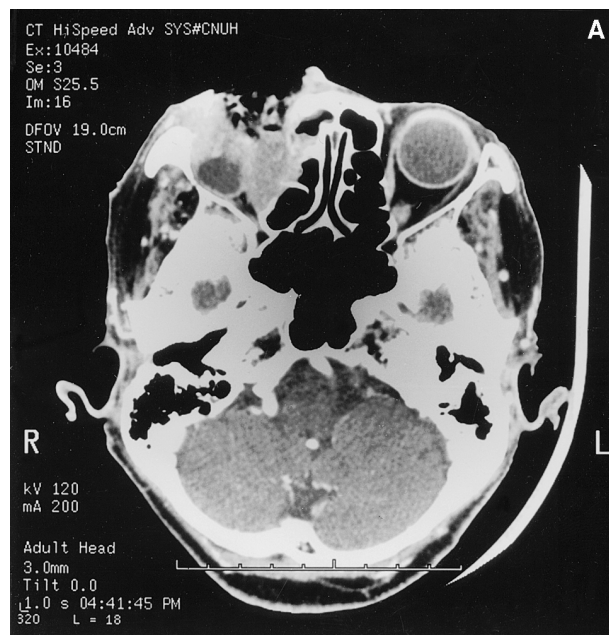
(A) Orbital sagittal computed tomographic scan showed mass in extraconal space of right orbit with extension to adjacent sinus cavity without brain involvement. It was surmised that remnant of eyeball remained in intraconal space. (B) Orbital coronal scan showed homogeneous mass, with extension to adjacent sinus cavity, had displaced remaining eyeball posteriorly.
